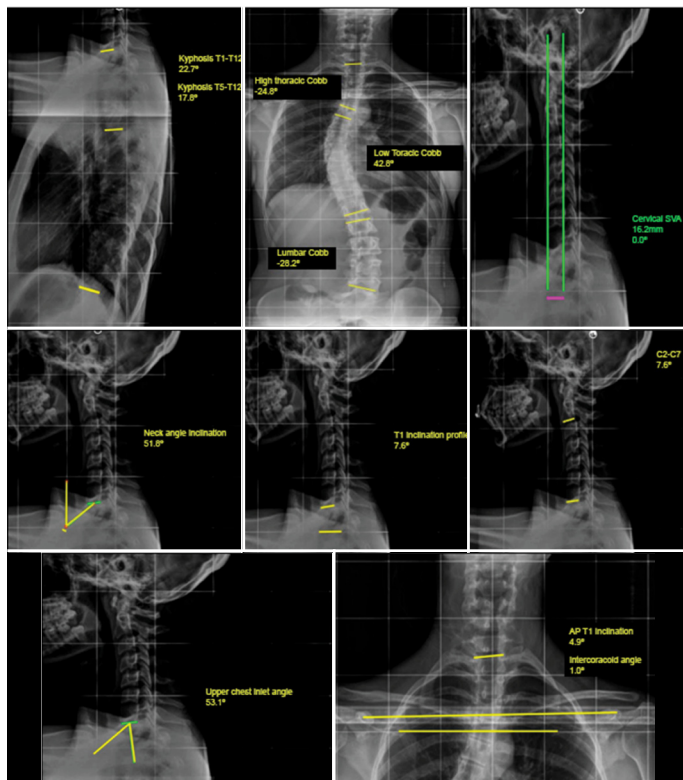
Representation of the radiographic measurements and parameters measured in patients with AIS.
